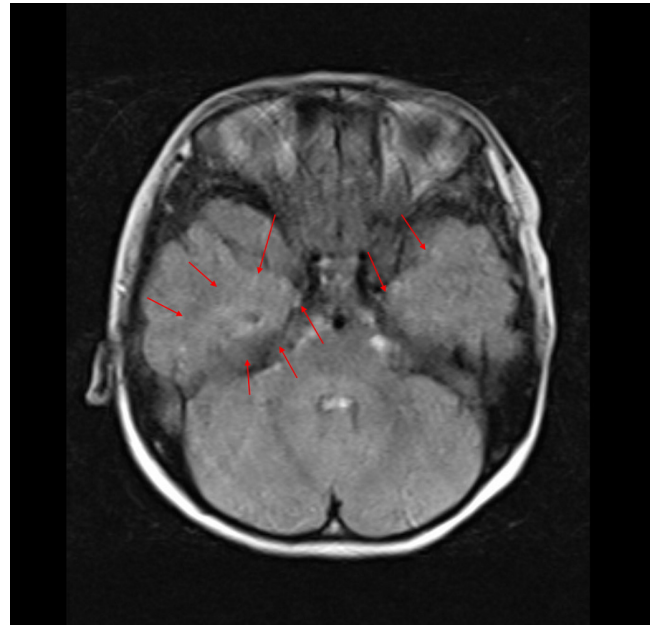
MRI brain showed ill-defined high signal intensity on T2 weighted image and FLAIR sequence over the medial temporal lobe. These findings may represent encephalitis.
